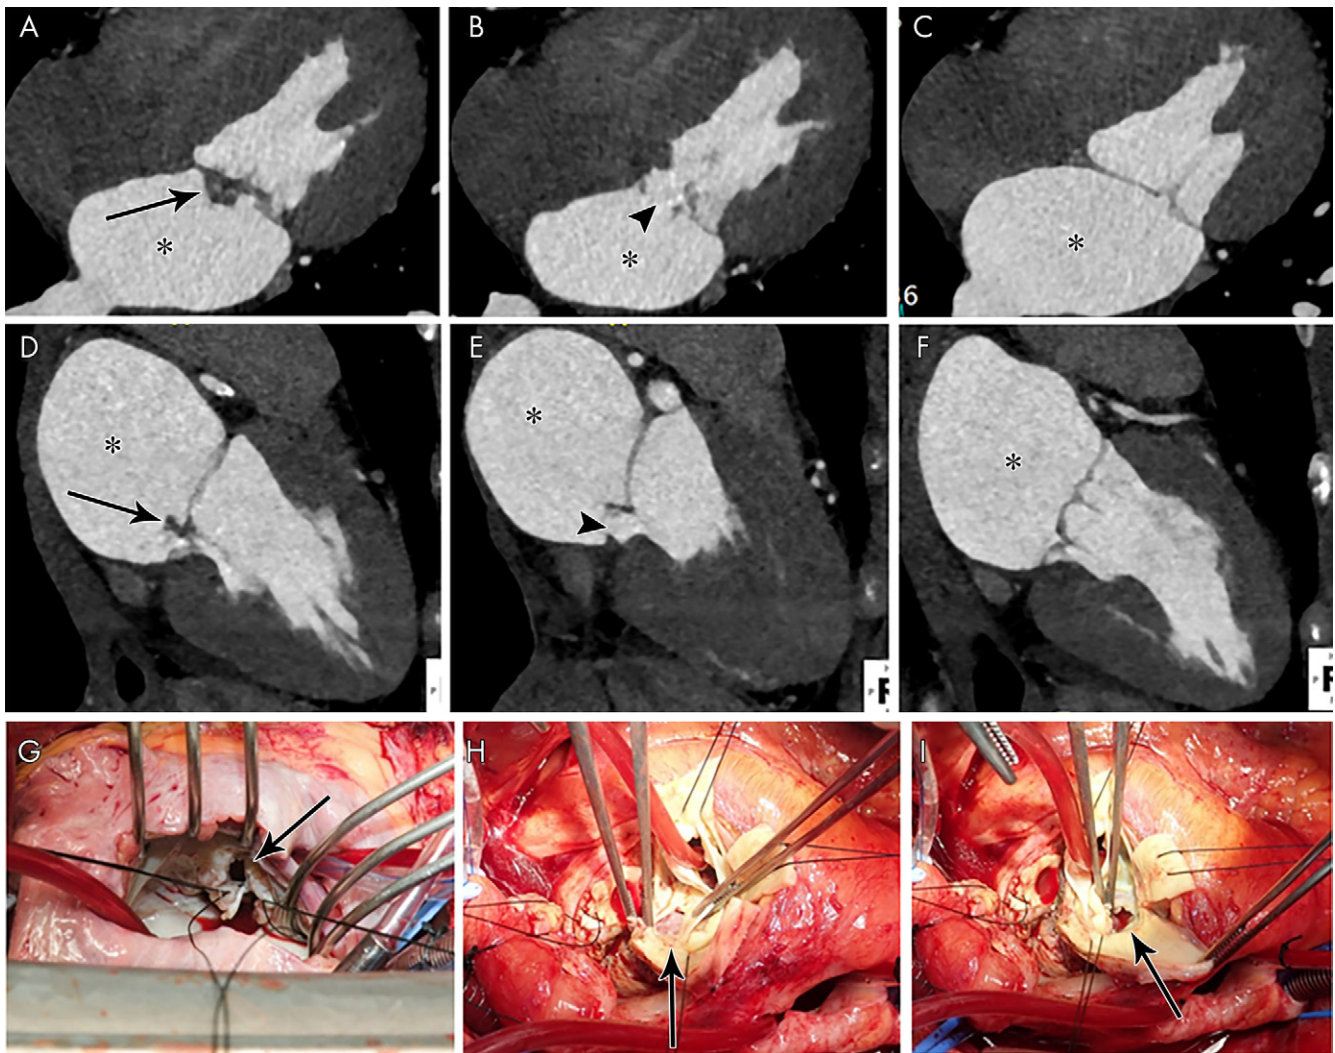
A–C, Four-chamber and, D–F, two-chamber contrast-enhanced CT images in a 39-year-old woman show focal ill-defined attenuation along the inferior aspect of the anterior mitral valve leaflet (vegetation, arrows) associated with leaflet perforation (arrowheads) and left atrial dilatation (*). G, Intraoperative image in a 32-year-old woman with infective endocarditis shows mitral valve leaflet perforation (arrow). H, I, Intraoperative images in a 49-year-old man with infective endocarditis show aortic valve leaflet perforation (arrows).
